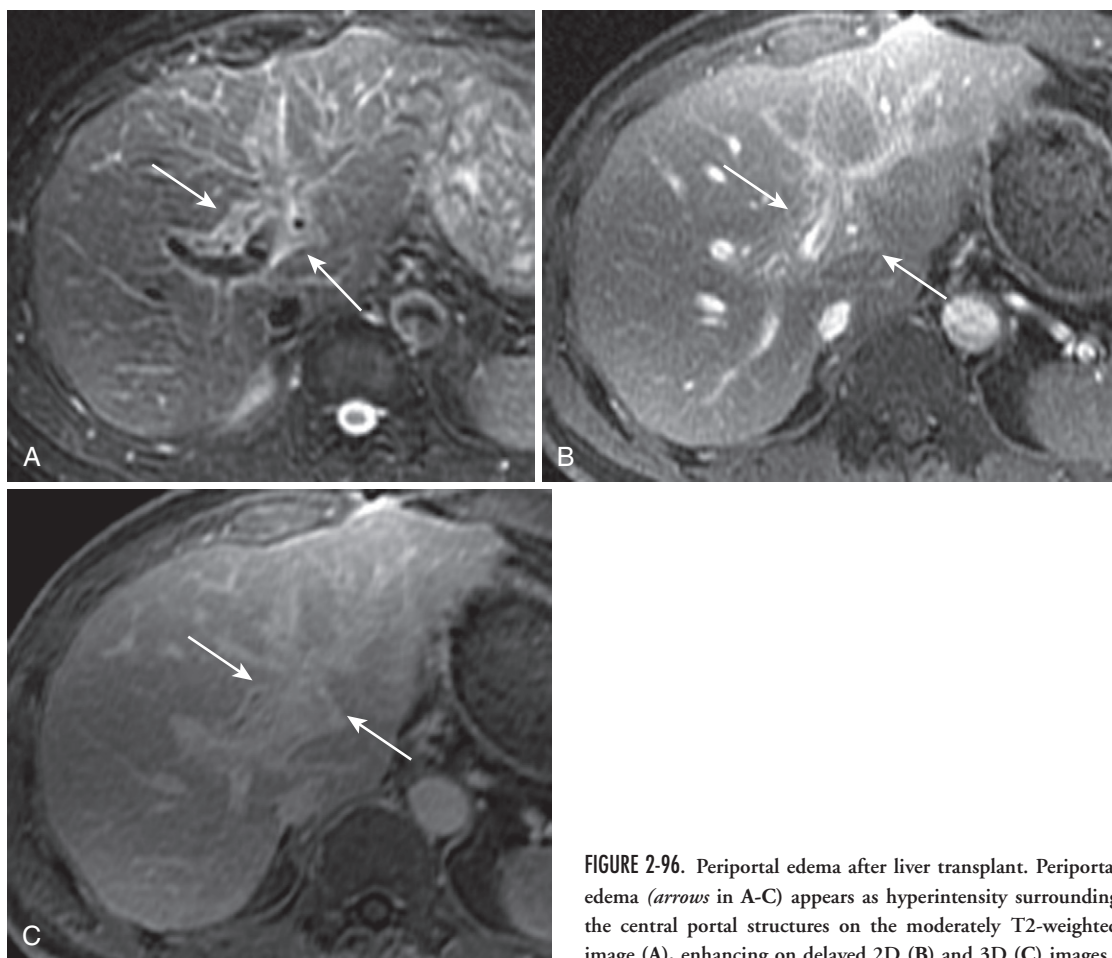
Periportal edema after liver transplant. Periportal edema (*arrows in A-C*) appears as hyperintensity surrounding the central portal structures on the moderately T2-weighted image (A), enhancing on delayed 2D (B) and 3D (C) images.
